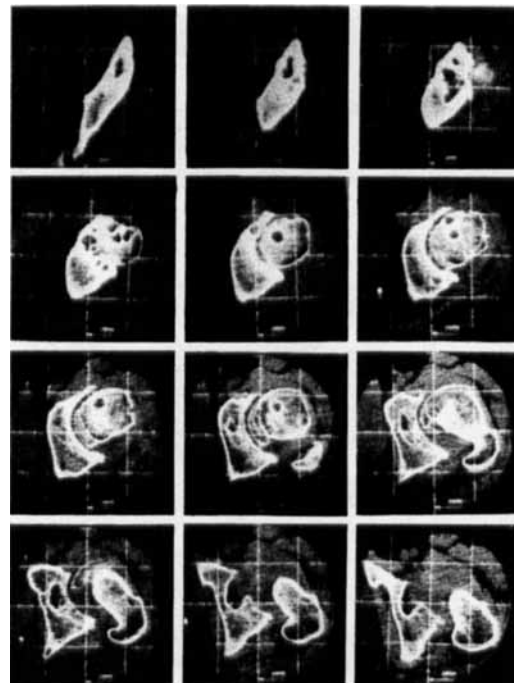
Hard copies of the CT image of Hip 3. Each slice has the same magnification and the same coordinates.
